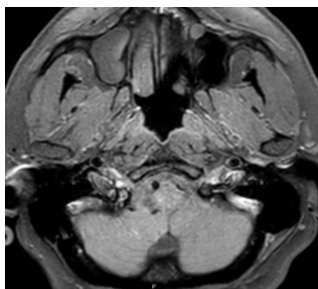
b. 5 years after treatment T2 axial MRI scan
